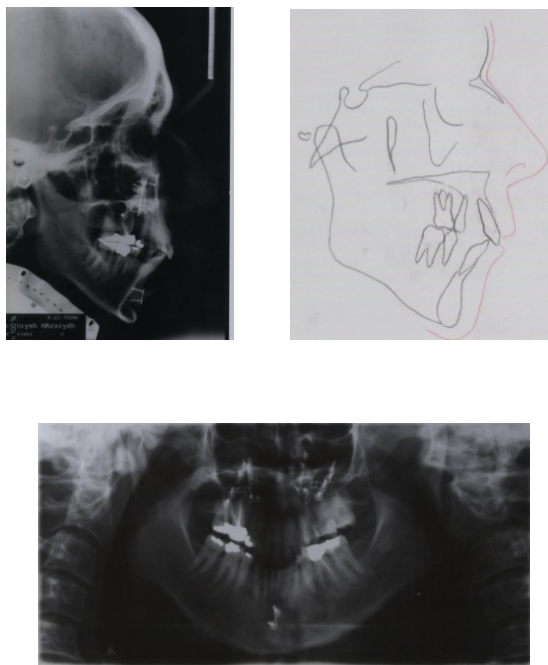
figs 14-a to 14-c, pretreatment cephalogram, cephalometric tracing and panoramic radiographs.
